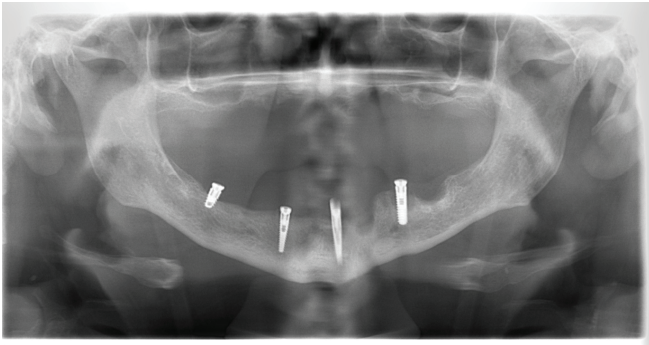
Preoperative radiographic image
